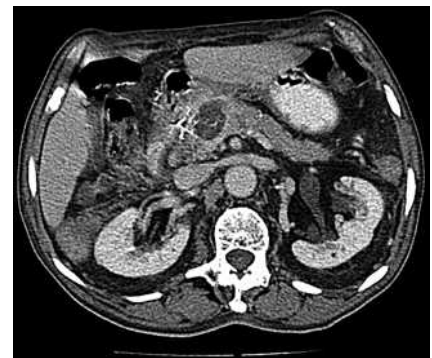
Abdominal CT scan showing a heterogeneous area in the pancreatic head.
